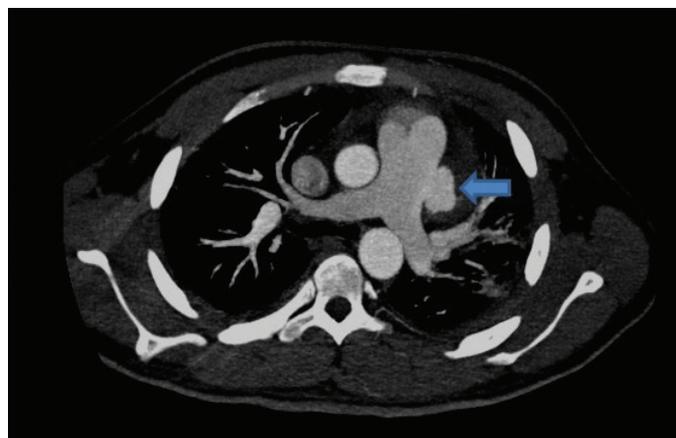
Computed tomography confirmed the association between the pseudoaneurysm (arrow) and the main pulmonary artery
